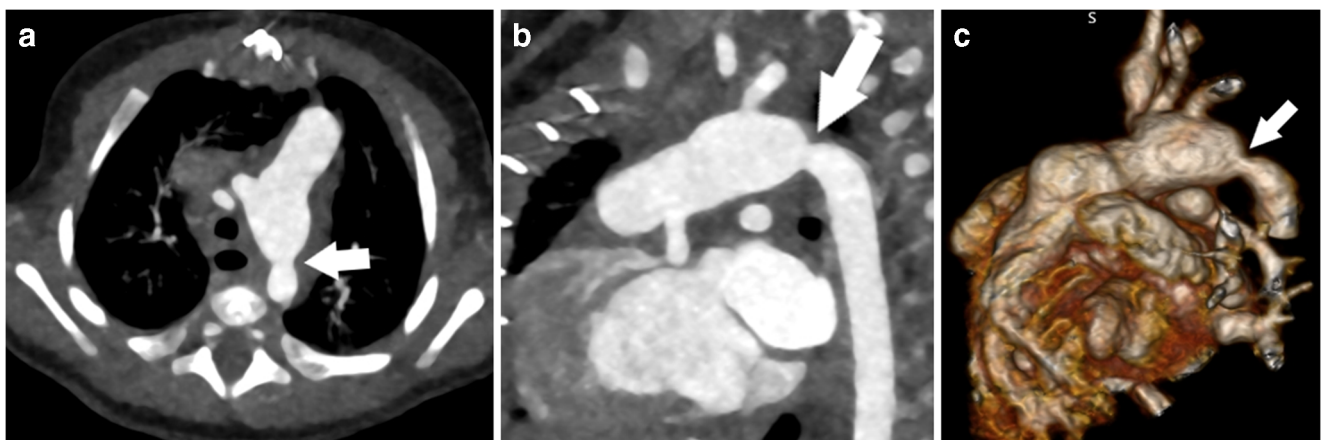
A 7-week-old girl with aortic isthmus stenosis. a–c Axial (a), sagittal (b) and three-dimensional rendered (c) cardiac CT angiography images demonstrate discrete moderate narrowing of the isthmus (arrows). The patient underwent balloon angioplasty by catheter angiography
